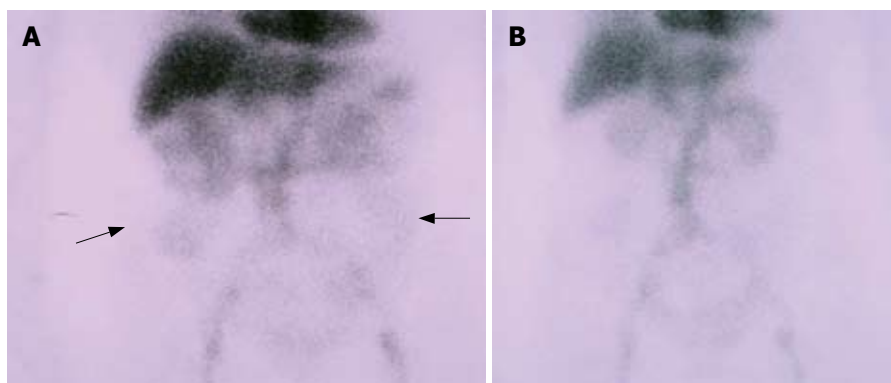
99mTc-human serum albumin scintigraphy shows leakage of the tracer in the large bowel (arrows) on admission (A) but no accumulation 1 mo after starting oral prednisolone (B).
